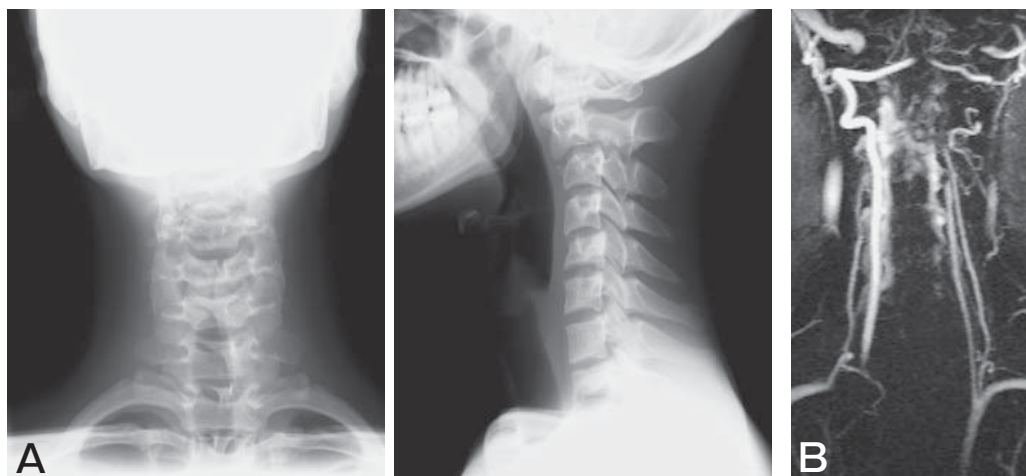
Preoperative roentgenogram and magnetic resonance angiography. A, Roentgenogram shows anterior slip of C2; B, Magnetic resonance angiography shows occlusion of the left vertebral artery.
